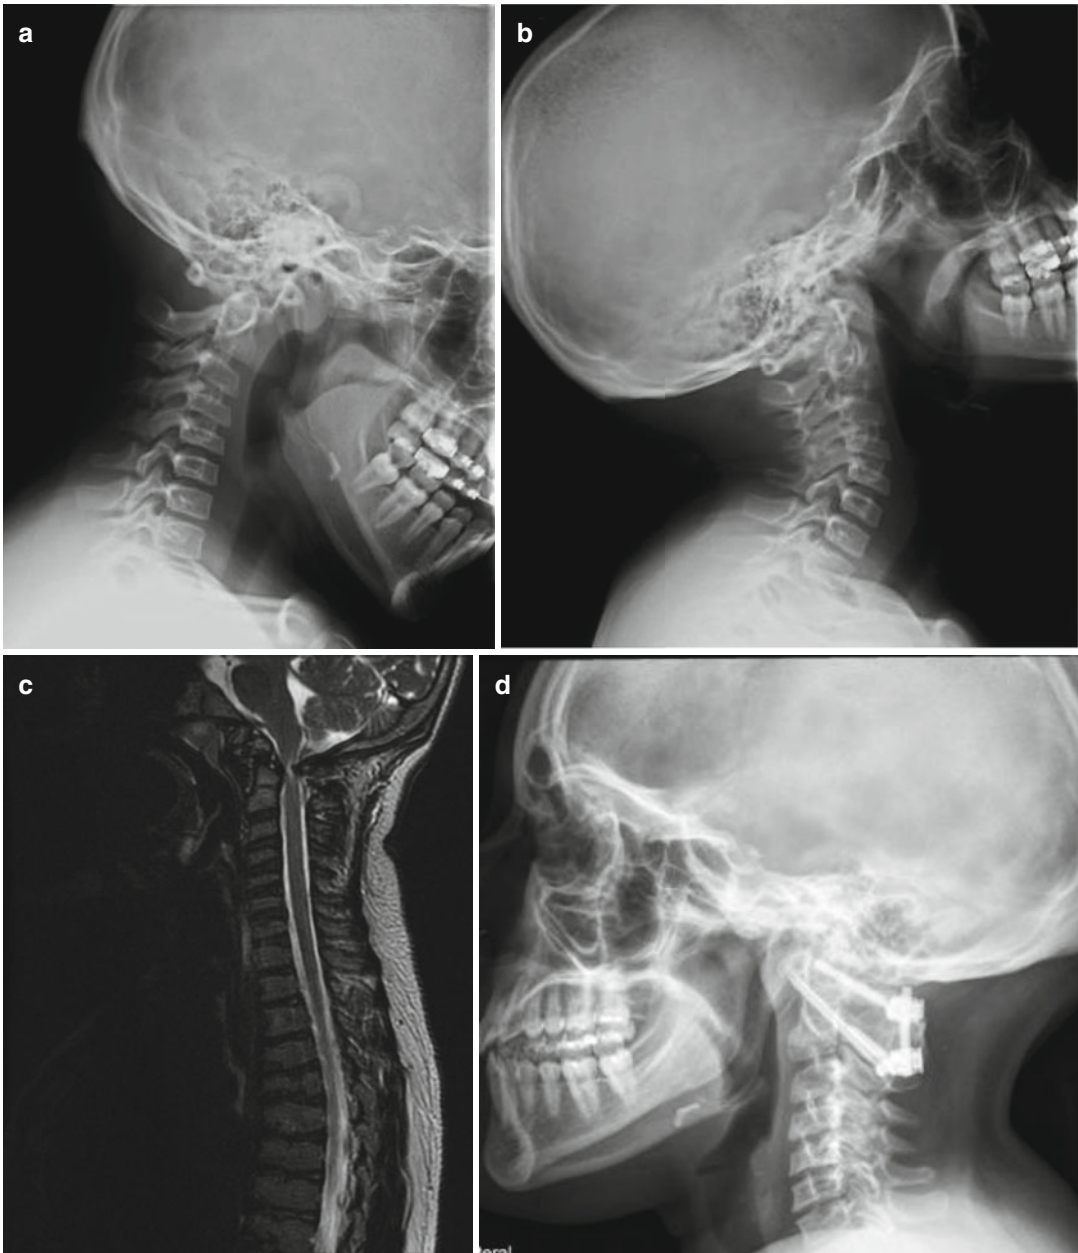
SEDC with C1–C2 instability in flexion (a) and extension (b) views. MRI (c) shows cervical stenosis and myelomalacia. C1–C2 decompression, instrumentation, and fusion were done as shown in (d)
